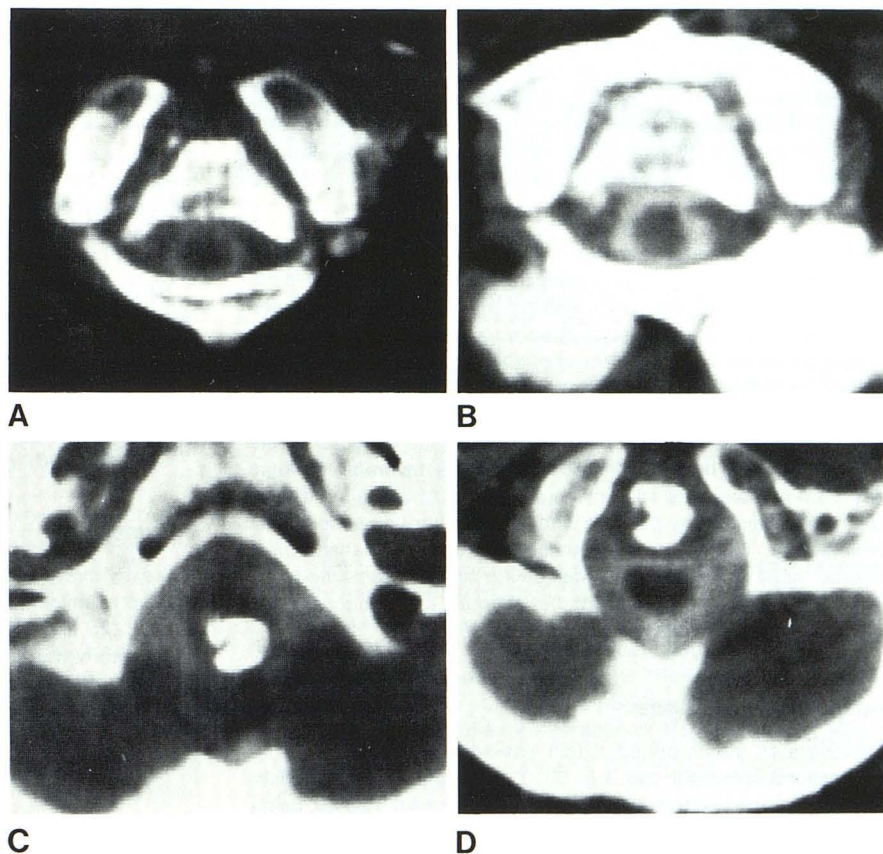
Flexion (A) and extension (B) metrizamide-enhanced CT examination of craniocervical junction at level of C2 in 50-year-old patient with basilar invagination and atlantoaxial subluxation. Flexion (C) and extension (D) studies at level of foramen magnum demonstrate basilar invagination and marked encroachment of dens into posterior fossa on flexion.
